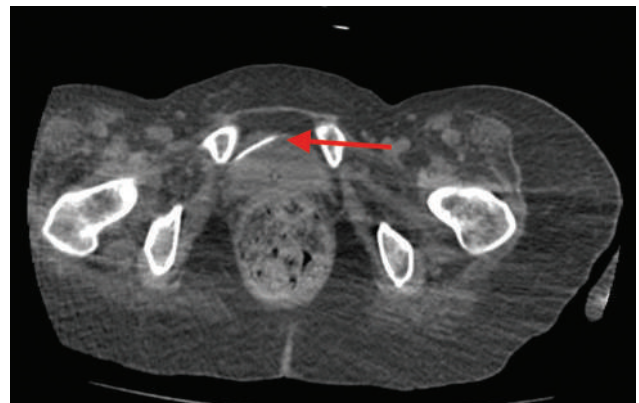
Abdominal CT scan (axial view): the distal catheter inside the bladder (red arrow).
